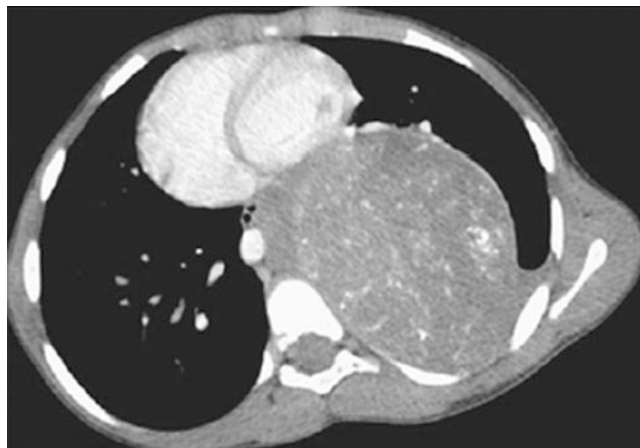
A 7-year-old boy who presented with difficulty breathing. Enhanced axial CT image demonstrates a very large mass in the posterior mediastinum with regions of enhancement and calcification proven to be a ganglioneuroblastoma
